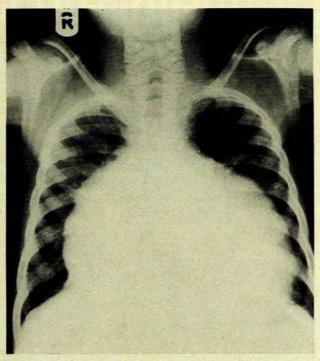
Chest radiograph of case 2.
